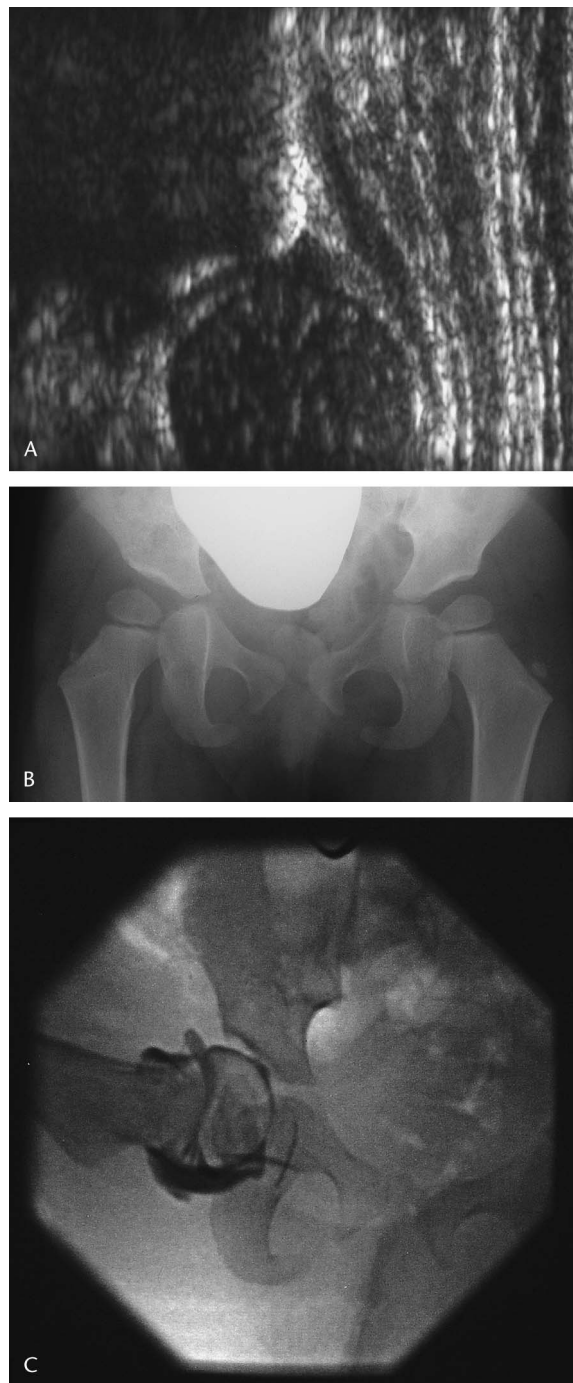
Late acetabular dysplasia of the right hip in a girl with bilateral DDH successfully treated in Pavlik harness. A, Coronal sonogram out of harness at time of weaning (age 3 months). Acetabulum is well formed, there is minimal rounding of the bony lip, and the labrum appears normal. B, Anteroposterior pelvis at age 2 years 11 months shows right acetabular dysplasia. Left acetabulum is normal. C, Arthrogram at age 2 years 11 months prior to Salter innominate osteotomy. The labrum is mildly elevated and blunted.
